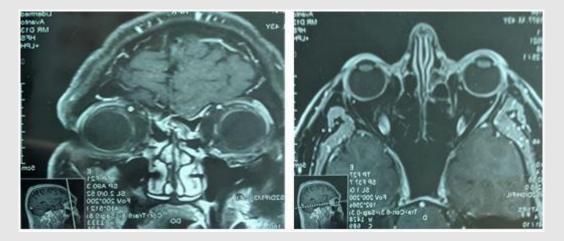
Series of MRI tomograms during a targeted examination.
